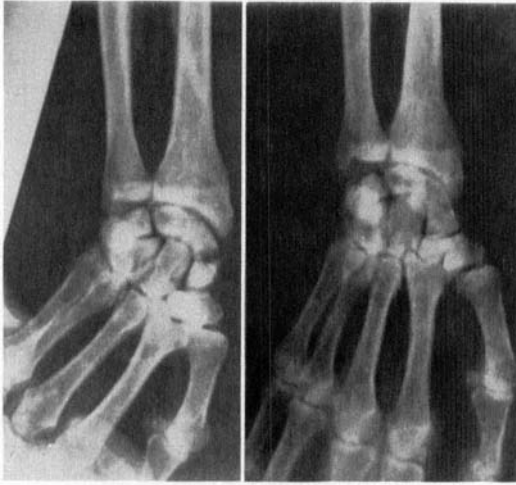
Radiographic verification of the observations in Figures 1 and 2.
